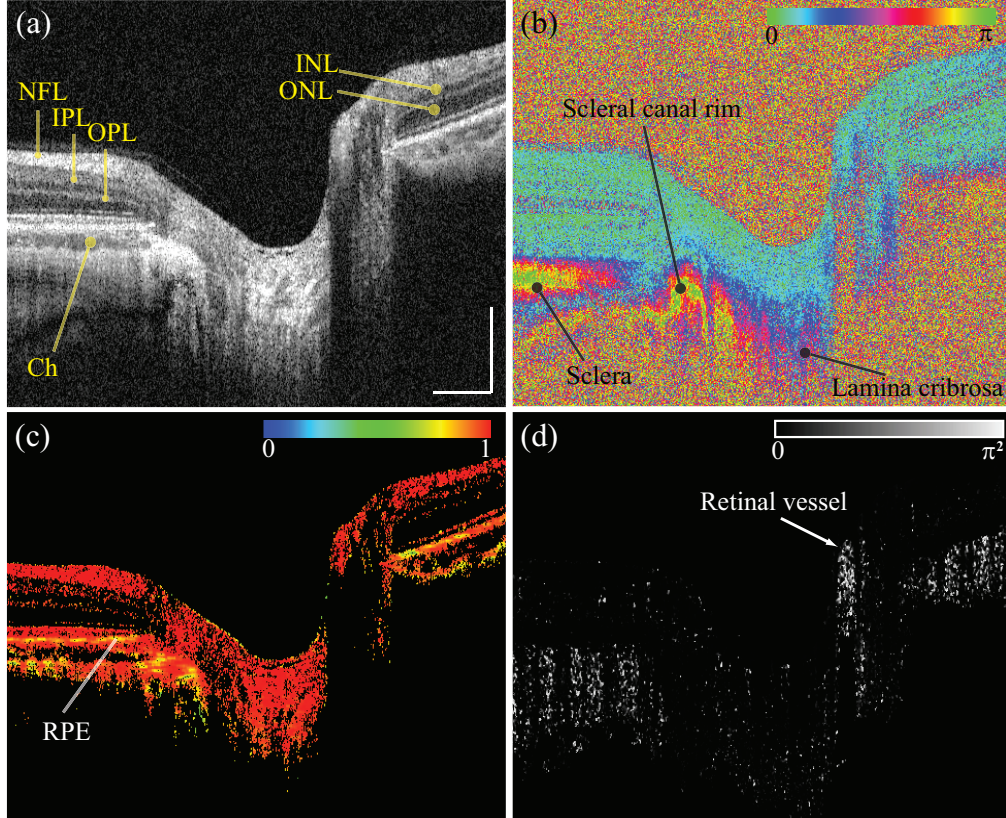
Jones matrix cross-sections of a normal ONH. (a) a global-phase-corrected sensitivity-enhanced scattering OCT, (b) phase retardation, (c) DOPU, and (d) power of Doppler phase shift. The scale bar represents  $500 \mu\text{m} \times 500 \mu\text{m}$ . (Source: Ju et al. *Advanced multi-contrast Jones matrix optical coherence tomography for Doppler and polarization sensitive imaging* [90])
